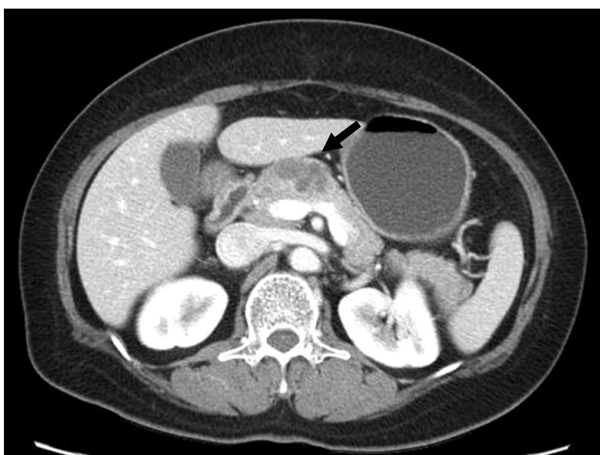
Follow-up abdominal CT finding 9 months after initial CT. It revealed a 3.3×2.2 cm cystic mass in the same area (arrow).
